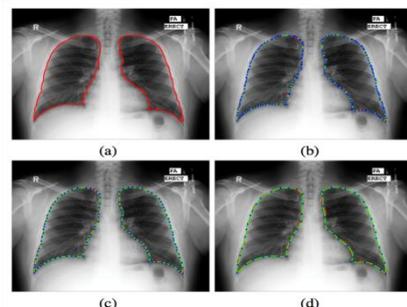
different type of graph cut segmentation for chest radiographs
